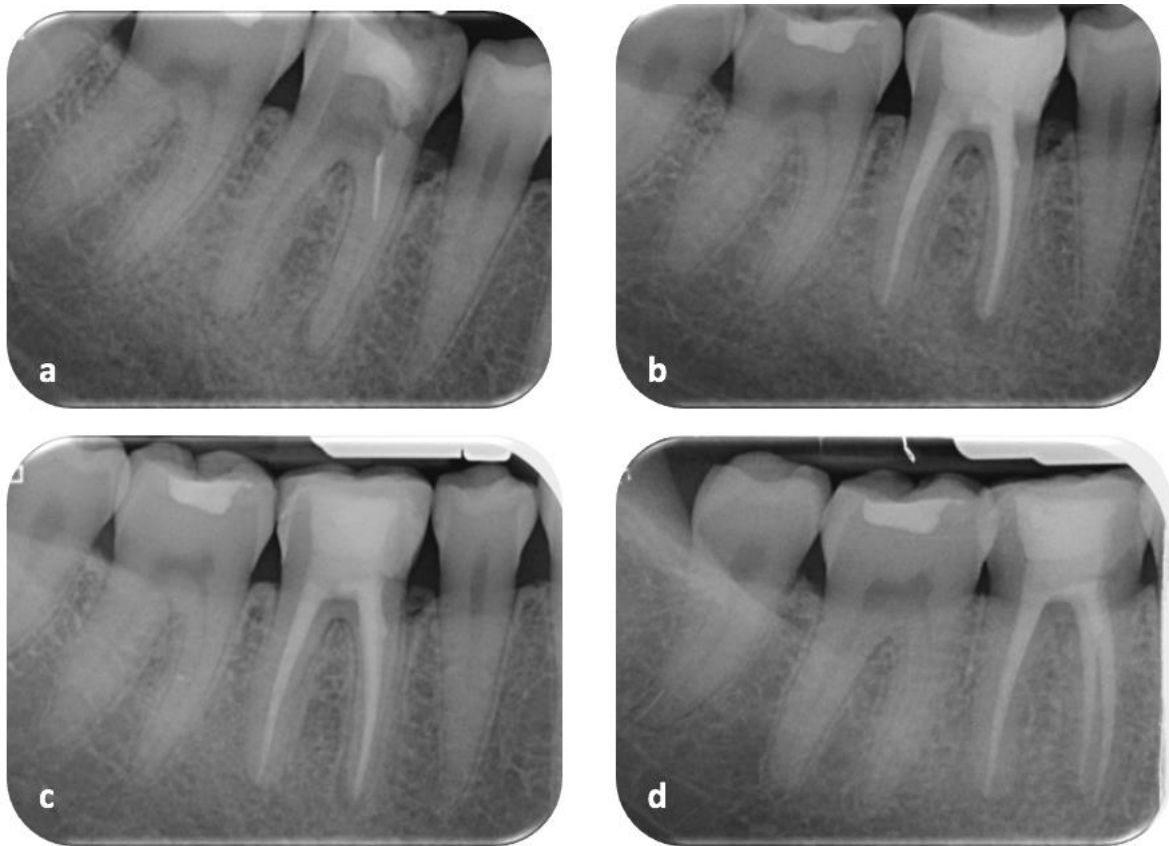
Review of tooth 36 (a) Pre-operative radiograph (b) Postoperative radiograph (c) 1-year review, showing periapical radiolucency is less dense (d) 2-year review, showing further reduction in the density and size of the periapical radiolucency
